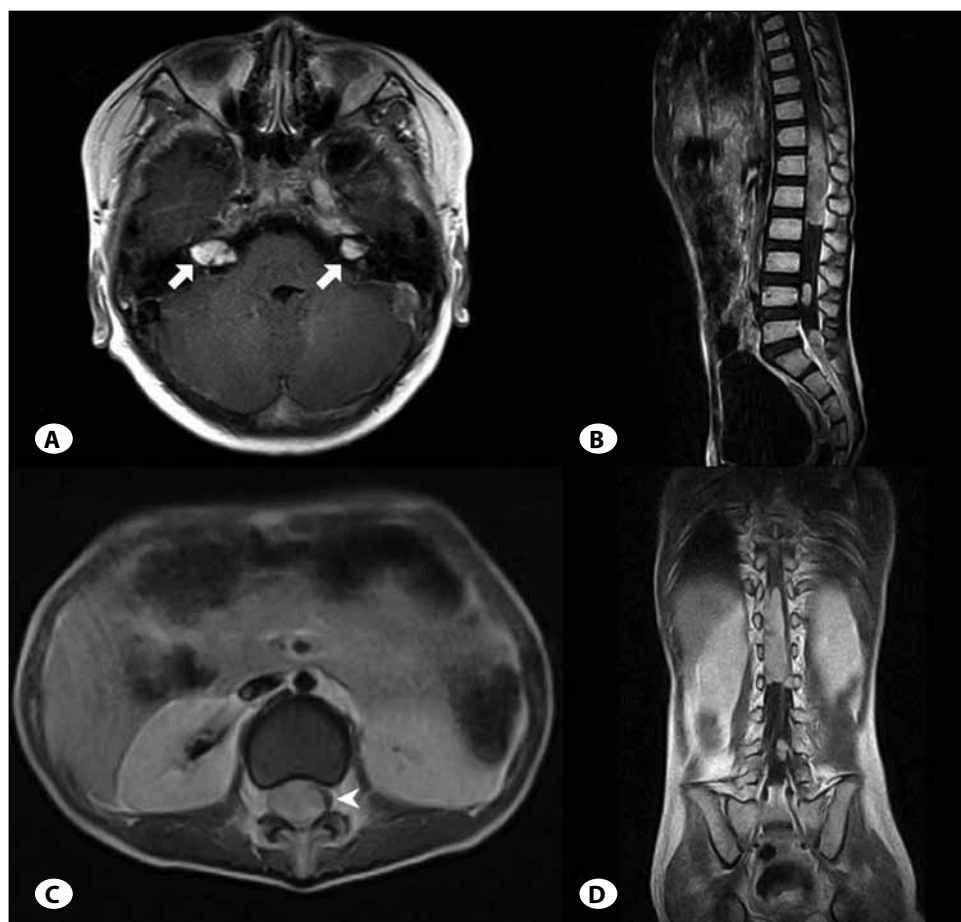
Axial (A) T1-weighted contrast-enhanced magnetic resonance (MR) imaging of the brain demonstrating bilateral vestibular schwannomas in the cerebellopontine area (arrow). Sagittal (B), axial (C) and coronal (D) T1-weighted contrast-enhanced MR imaging of the lumbar spine showing multiple intradural masses, causing the spinal cord was severely compressed and displaced to the left (arrowhead).
